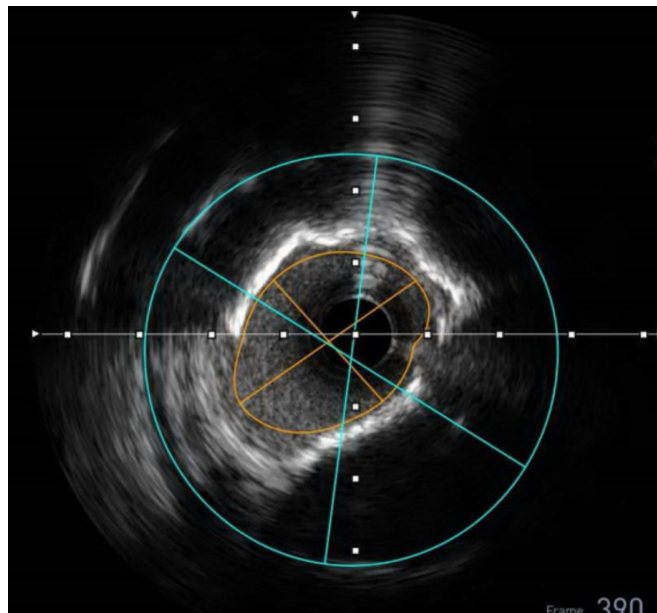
Postangioplasty intravascular ultrasound images.
